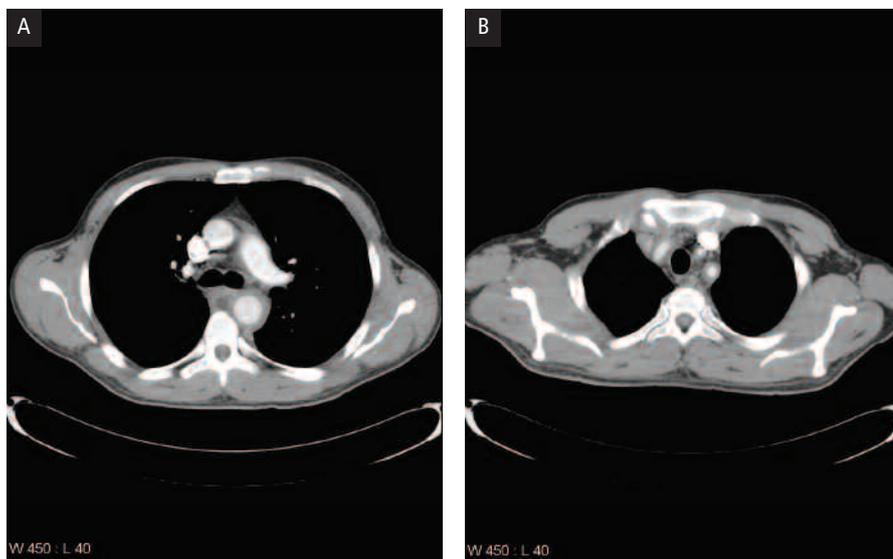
Computed tomography imaging of the thorax. *A*, Circumferential thickening of the wall of the aortic arch and descending thoracic aorta. *B*, Circumferential thickening of the great vessels arising from the aortic arch, including the innominate artery, the right and left common carotid arteries, and the right and left subclavian and axillary arteries.
